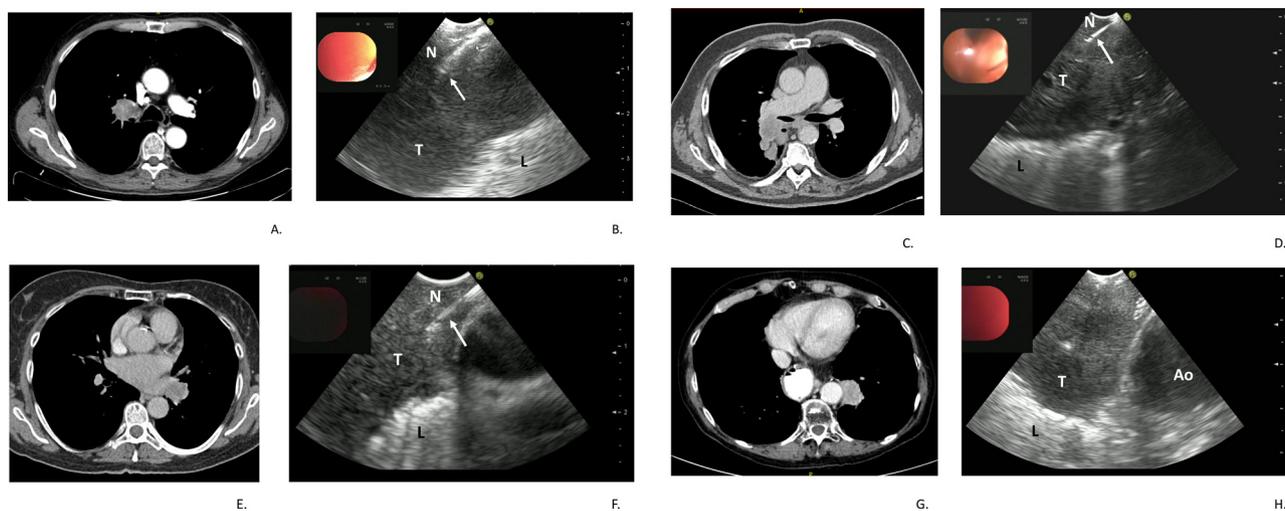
EBUS-TBNA sampling stratified for tumor location relative to the tracheobronchial tree. Pictures A, C, E and G show CT images of centrally located lung tumors (T) adjacent to trachea, main bronchi, lobar bronchi and segmental bronchi, respectively. Figures B, D, F and H show the correspondent EBUS-TBNA procedural images. The needle (N), when present in EBUS images, is signaled by arrow tips. L = compromised lung parenchyma, Ao = aorta.
